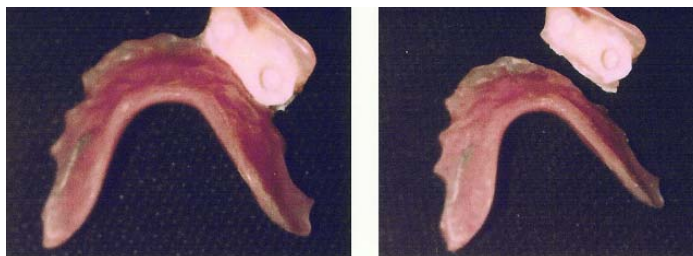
Tissue surface of interim partial denture was channeled and obturated with gutta-percha, which served as radiographic CT scan markers for implant planning and placement.
